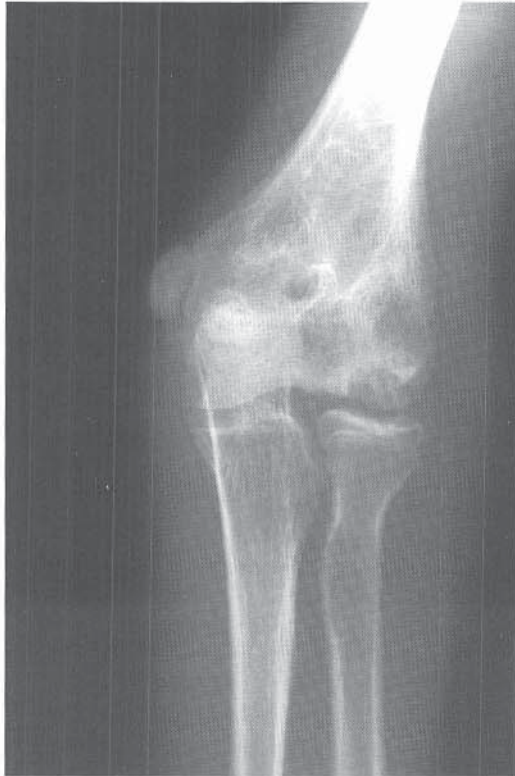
AP radiograph demonstrating osteonecrosis of the capitellum in a 13-year-old.
